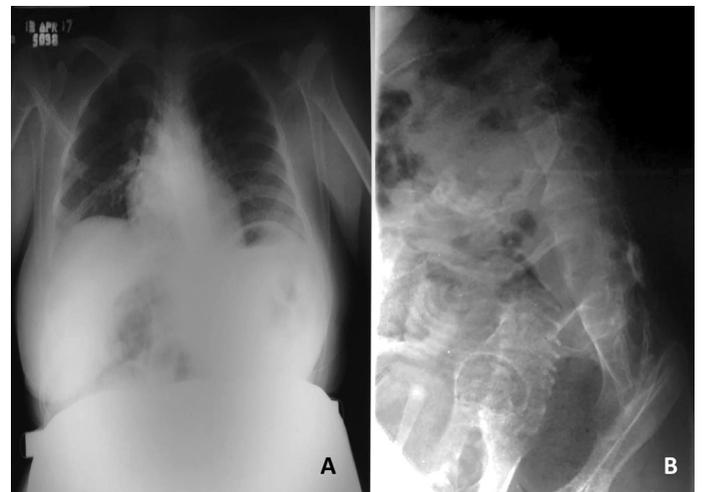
(A) Chest anteroposterior radiography (B) Lumbosacral radiography, There is note of a free space between L4-L5.
